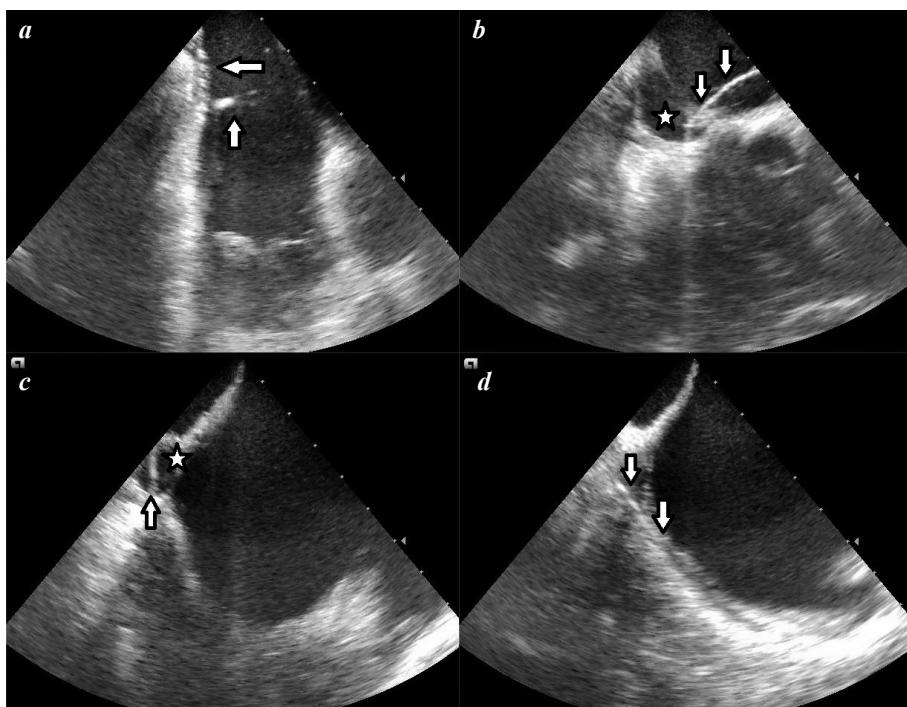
Catheter positioning under intracardiac echocardiography (ICE) guidance: (a) the ablation catheter (horizontal arrow) positioned at the central portion of the cavotricuspid isthmus (CTI); the pronounced length of the isthmus is notable; (b-d) placement of the diagnostic 10-pole catheter (vertical arrows) into the coronary sinus; the asterisk indicates the coronary sinus ostium.
